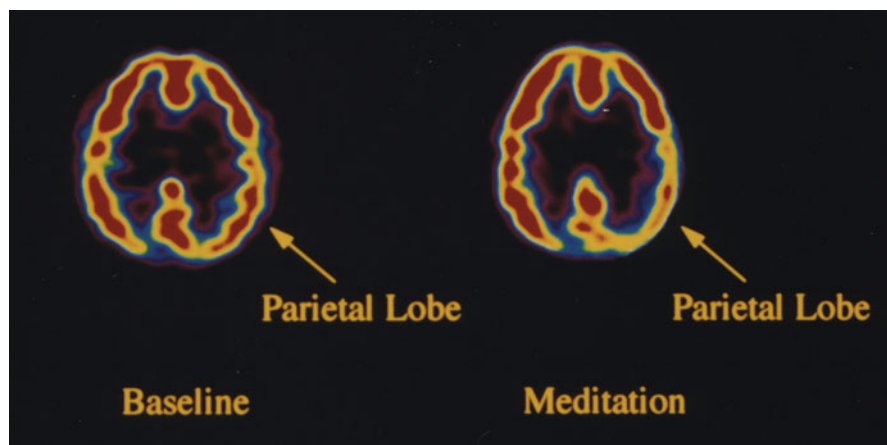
SPECT scan of meditation showing reduced cerebral blood flow during meditation in the parietal lobes consistent with the loss of the sense of self
